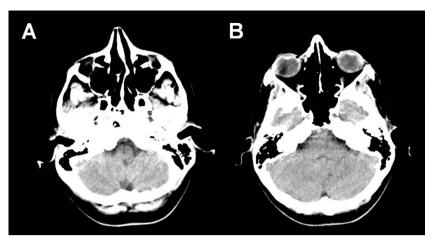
Axial CT scan imaging shows absence of sinonasal and orbital pathology.
